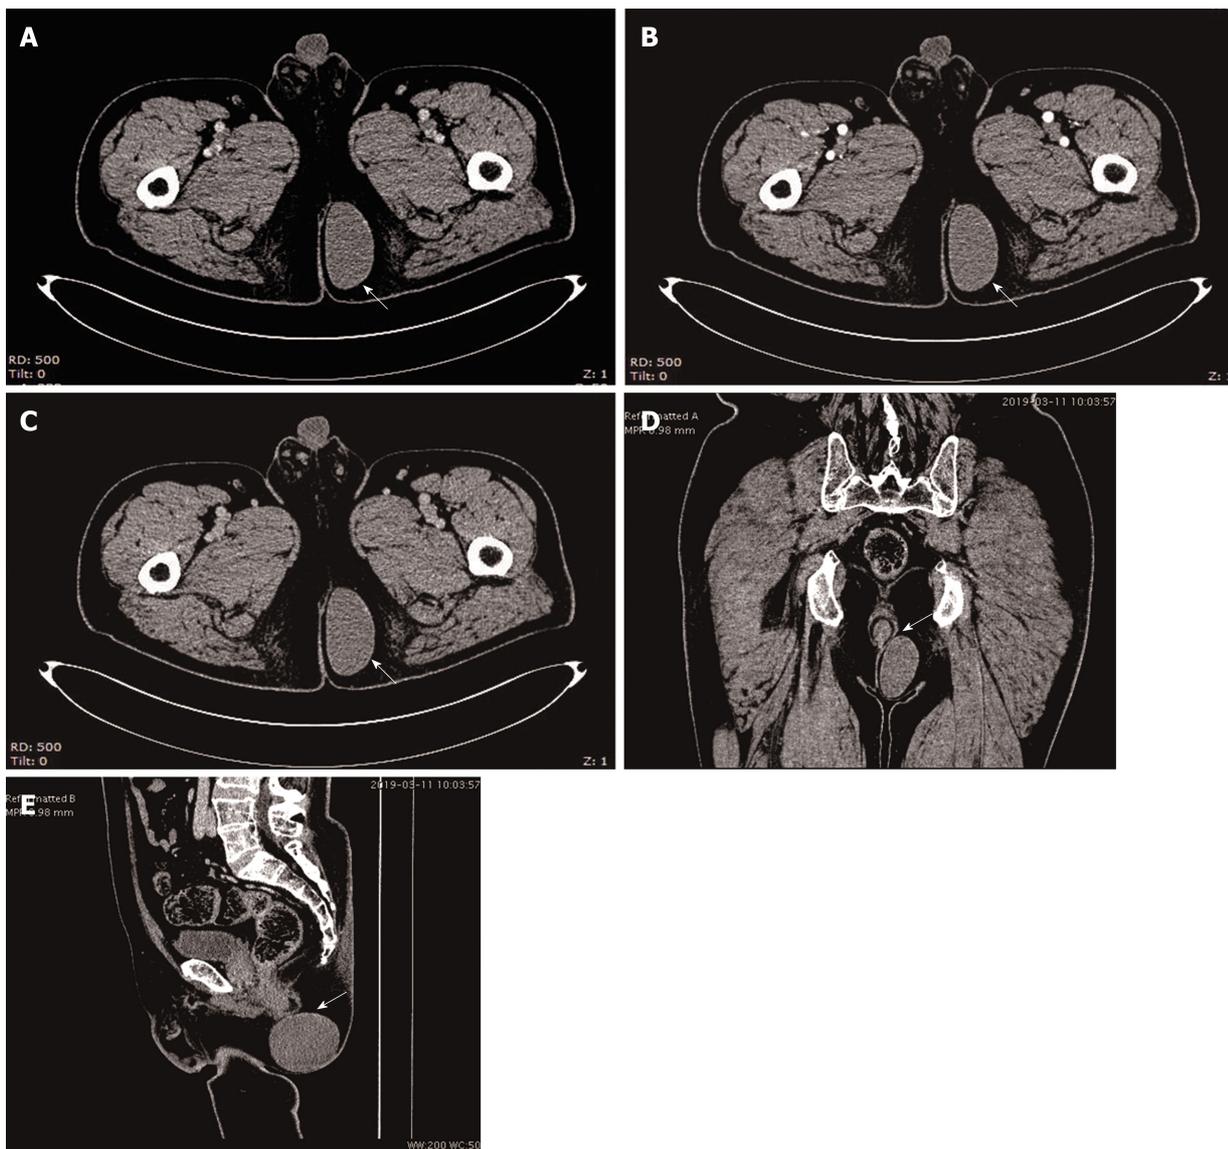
Contrast-enhanced computed tomography images. A-C: Contrast-enhanced computed tomography images revealing a cystic low density shadow with a smooth edge. The wall of the cyst was not enhanced and there were no blood vessels in and around the mass in the venous phase, arterial phase, and delayed phase; D and E: The upper right edge of the mass was very close to the anal canal.
